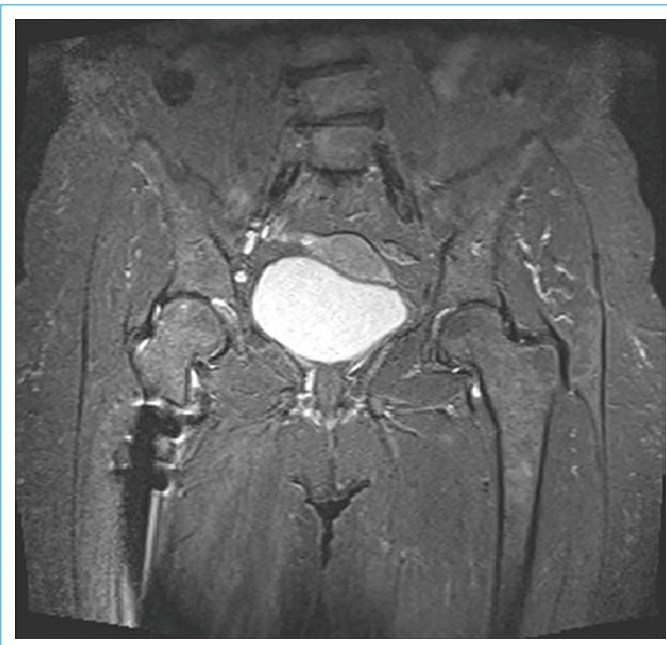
Coronal T2-weighted magnetic resonance image of a 29-year-old female patient with slight right hip dysplasia, lumbar scoliosis, and metallic artifact secondary to derotation osteotomy in the right femur.
